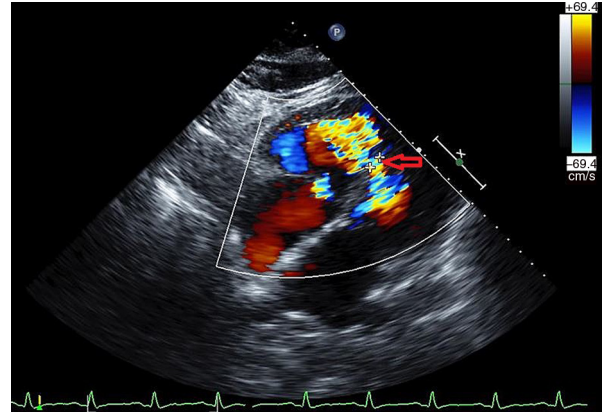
Echocardiogram with color Doppler displaying a ventricular septal defect postmyocardial infarction (arrow).
